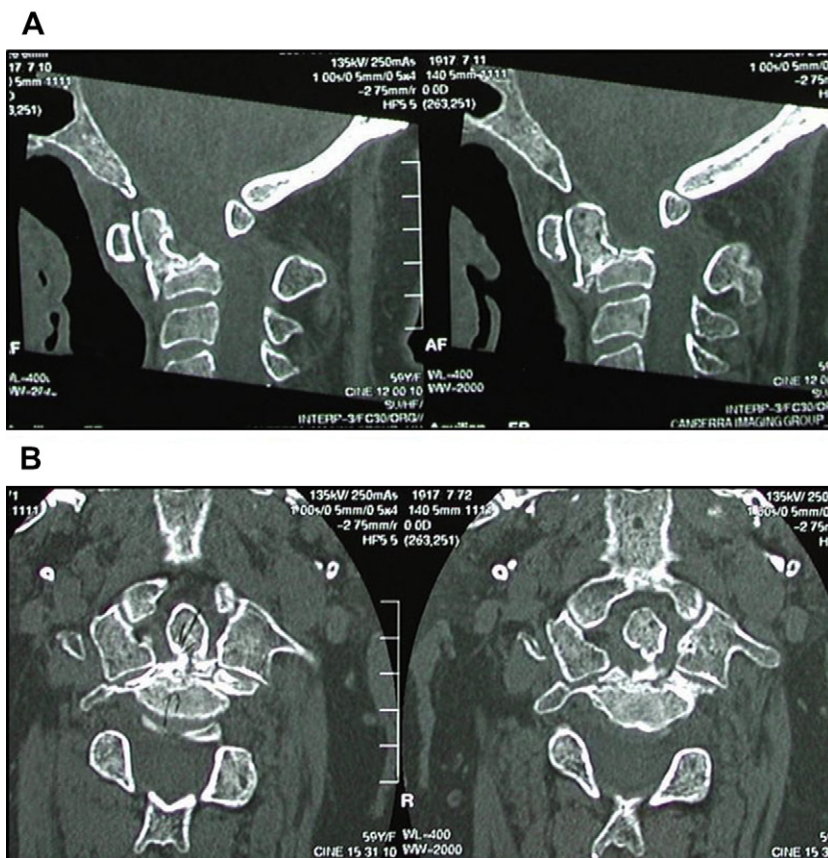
CT scan of sagittal and coronal reconstructions showing (A) orientation of planned osteotomy and (B) bilateral extent of base of osteotomy.
